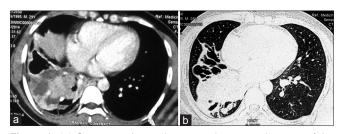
(a) Contrast-enhanced computed tomography scan of the thorax (mediastinal window section) demonstrating a mass in relation to the bronchus intermedius with distal lung parenchyma showing volume loss and mucoid impaction. (b) Computed tomography scan of the thorax (lung window section) demonstrating bronchiectatic changes in the right lower lobe distal to the obstruction
